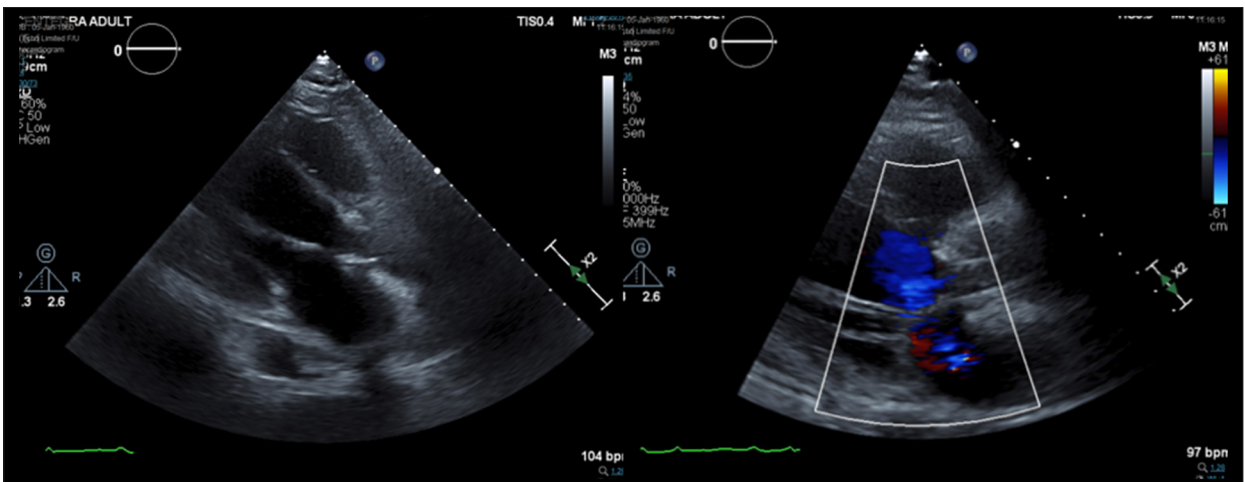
Follow up transthoracic echocardiogram (TTE), 1 month after surgical aortic valve replacement showing no evidence of aortic valve regurgitant blood flow on colored doppler.
